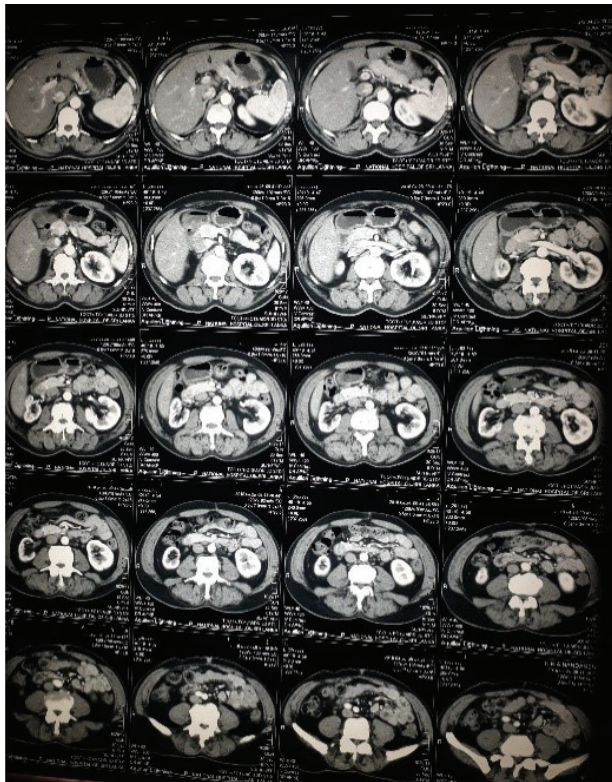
Printed CT image containing additional panels which are not relevant to the pathology (reported as bladder tumour causing bilateral hydronephrosis).
